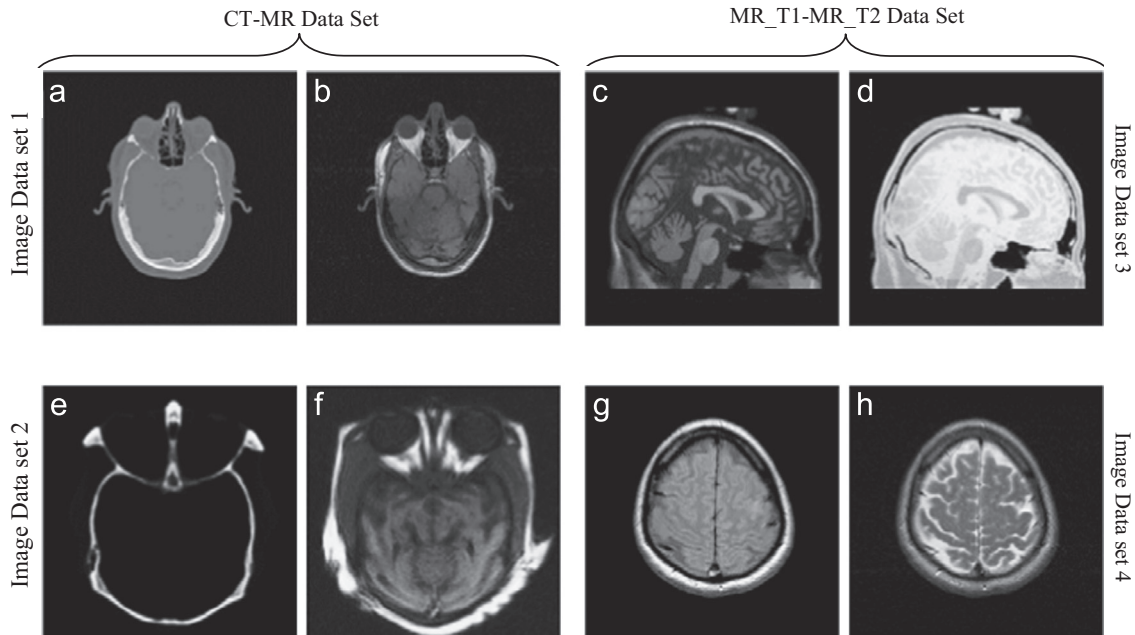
Multimodal medical image data sets: (a,e) CT image, (b,f) MR image, (c,g) MR-T1 image, and (d,h) MR-T2 image.
